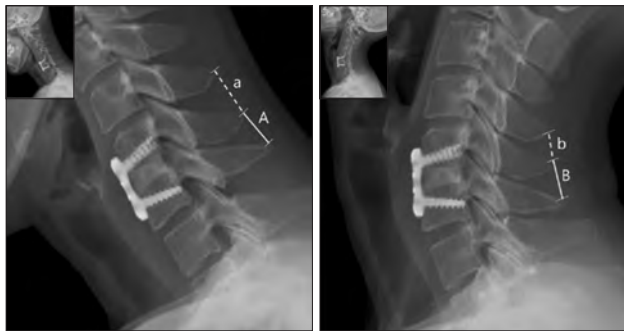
Interspinous motion (ISM) in cervical lateral radiographic views. The images were enlarged by 150% to facilitate the evaluation of ISM. The ISM was defined as the difference in the interspinous distance between lateral flexion and extension radiographic views on an operative segment ($ISM = A - B$). The criteria for fusion based on plain radiographic ISM was < 1 mm at the arthrodesis level and > 4 mm at the non-arthrodesed superjacent level (the level above the fused area, $a - b$).
